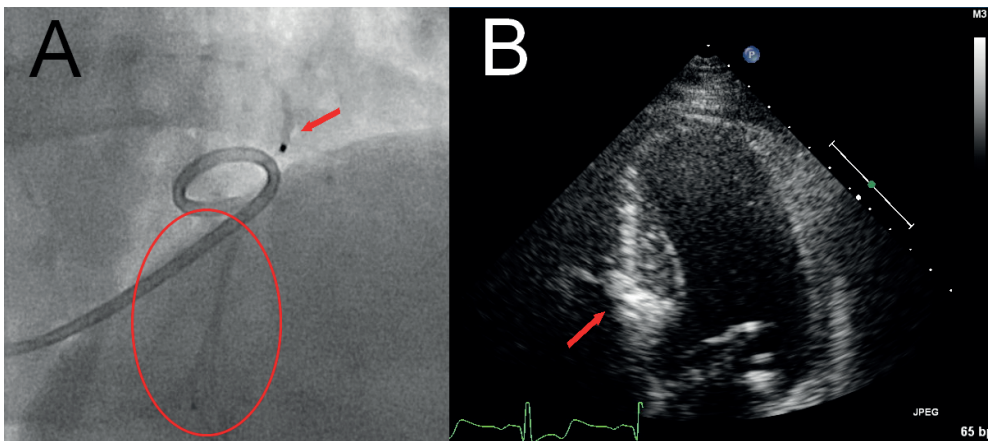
Balloon inflation (A) in targeted septal artery (red arrow) and contrast agent downstream of the balloon (red circle). Opacification of the targeted septal area on 2D echocardiography (B).
